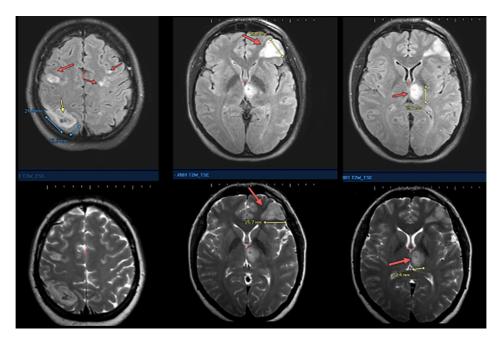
Cerebrum structures embolism due to vegetations in T2 FLAIR and T2WI modes: multiple hyperintense subcortical lesions in both cerebral hemispheres, in left frontal cortex and left thalamus
